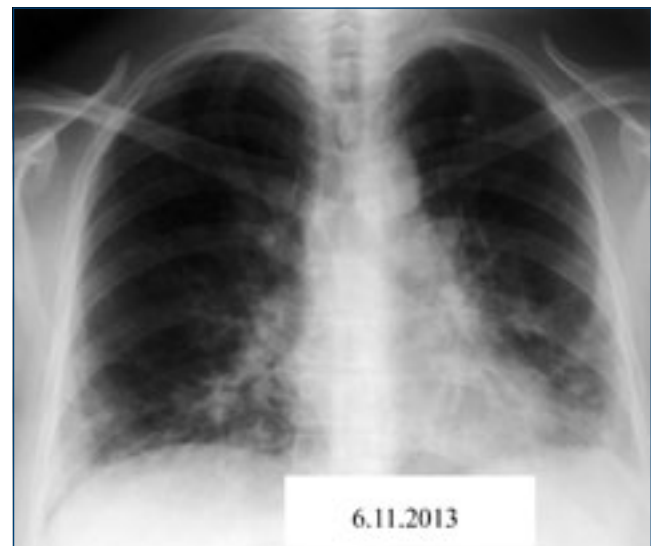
After a week of discontinuation of antiviral treatment and institution of antibiotic treatment, frontal radiograph showed a resolution of some infiltrates, but the maintenance of linear and ground glass opacities in the lower lung fields
